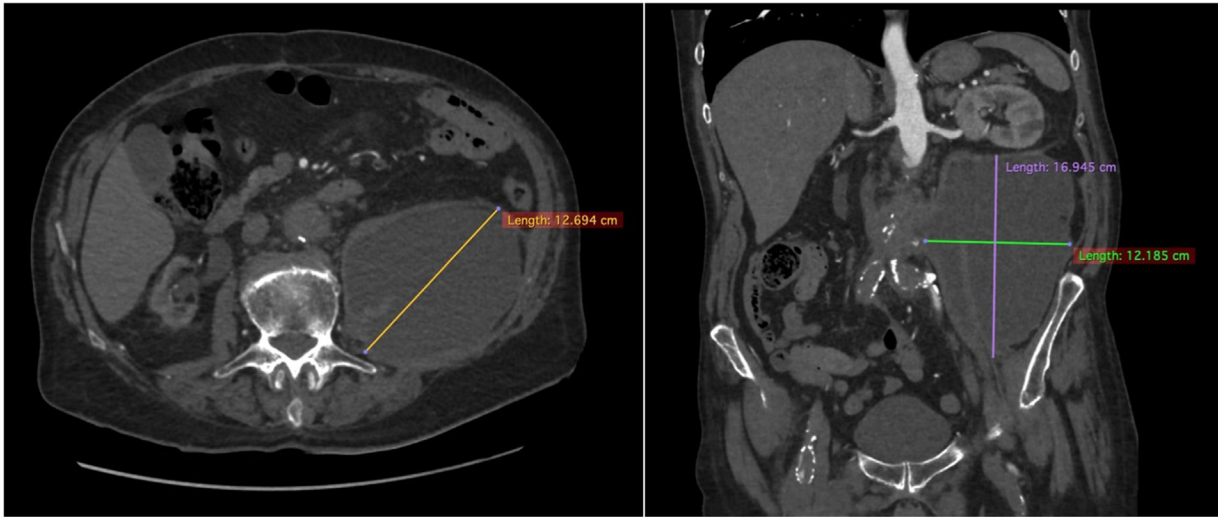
Computed tomography angiography (CTA) showing voluminous retroperitoneal abscess.
